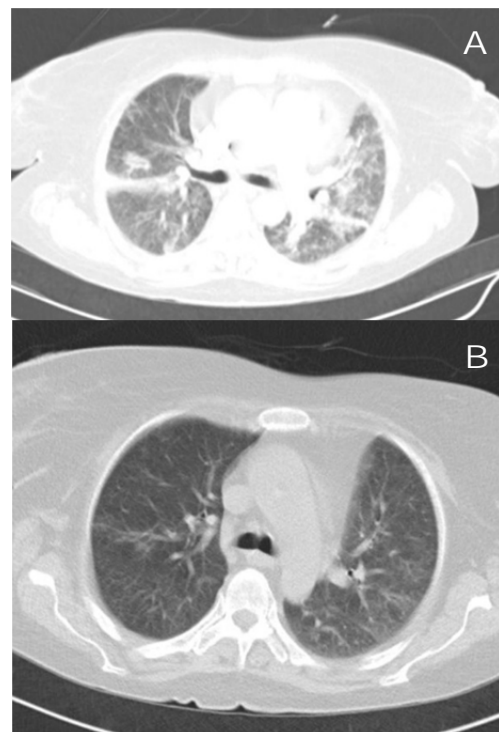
Patient's CT-scan at her second admission. A) at the day of admission B) one week after hospitalization
